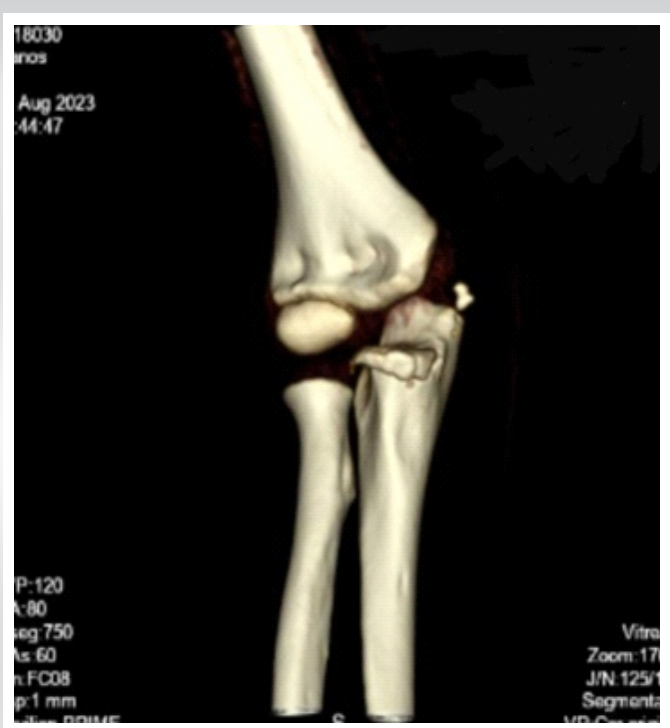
Pre-operative 3D reconstruction computed tomography scan confirming a fracture of the coronoid process.
